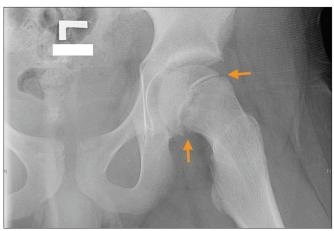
Frog-leg radiograph of the left hip revealing early slipped capital femoral epiphysis, which is evidenced by inferior slippage of the femoral head (arrows).
